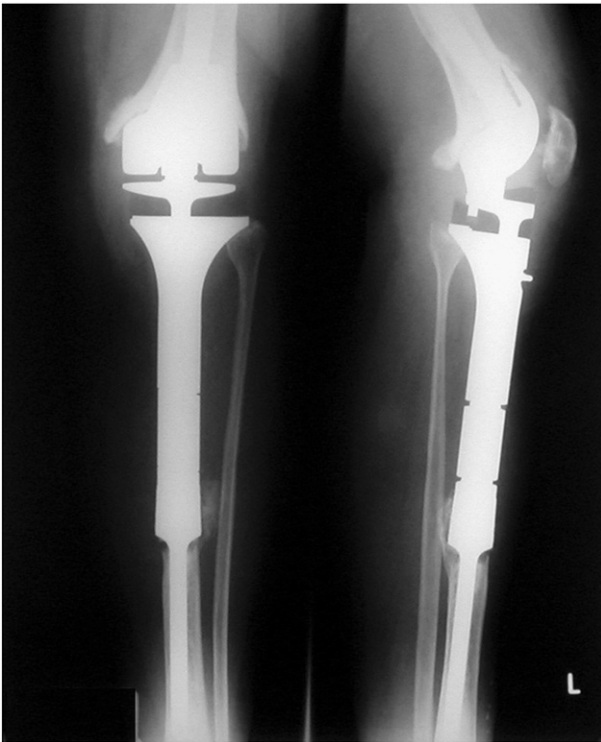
Radiographs of the left knee in anteroposterior and lateral views show status post-wide excision of tumor and total knee arthroplasty with rotating hinge megaprosthesis.
